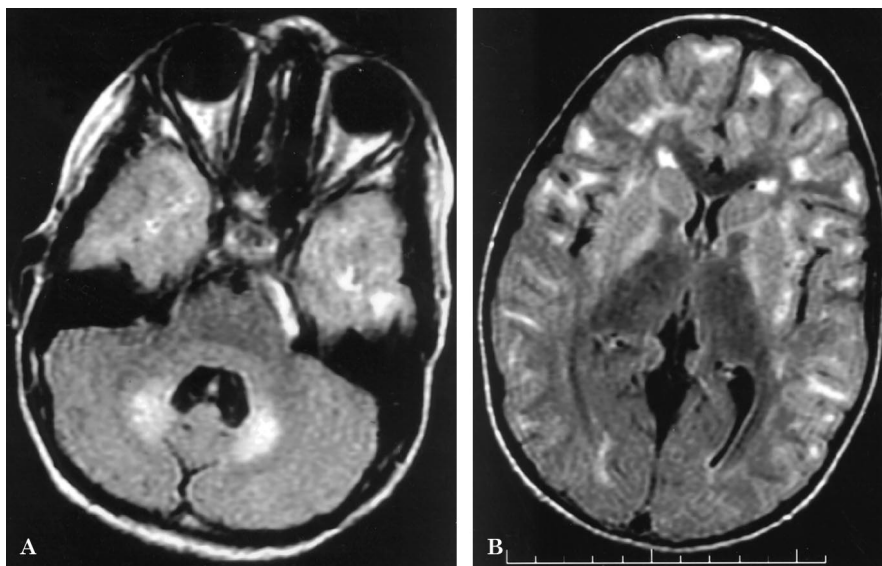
Fluid attenuated inversion recovery MRI shows T2-hyperintensities in the subcortical white matter and the dentate.
